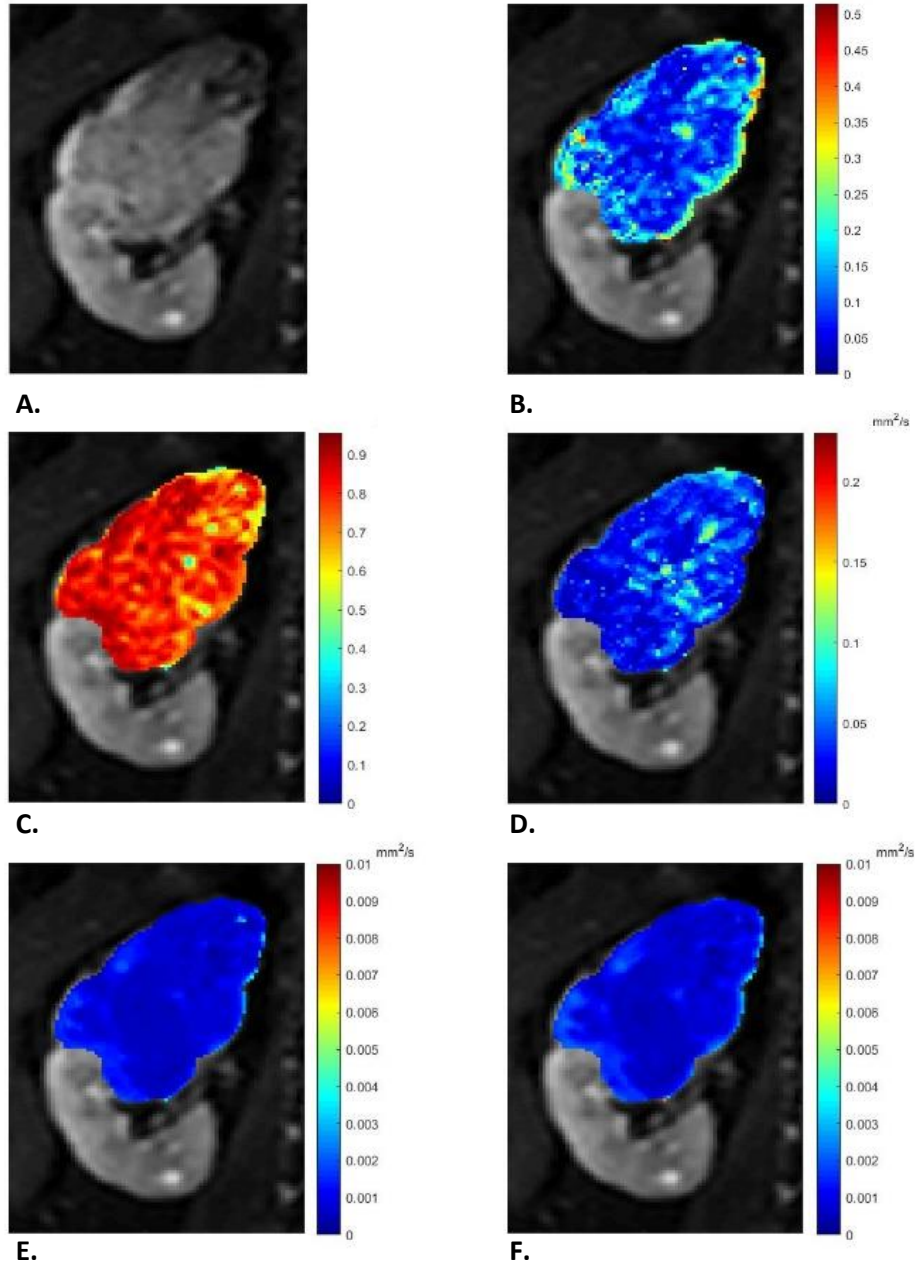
Parameter maps of multi-exponential DWI models of a papillary renal cell carcinoma. In A the b_0 -image is shown. Parameter maps of IVIM parameters f , D_p and D_t are shown in B, D and F, respectively. Parameter maps of stretched exponential parameters α and DDC are shown in C and E, respectively.
